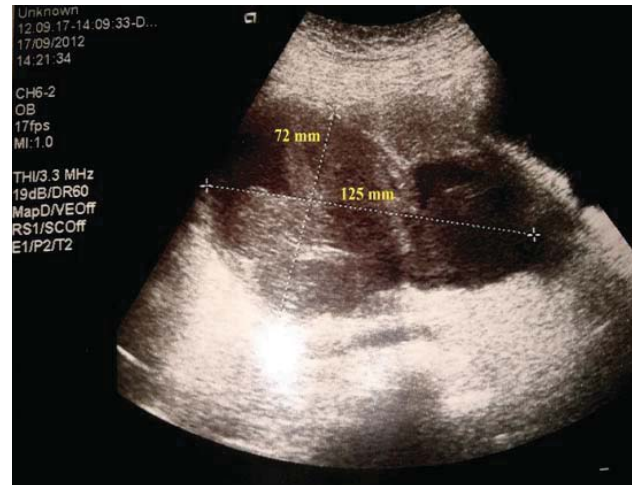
Preoperative transvaginal ultrasonographic view of the pelvis.
